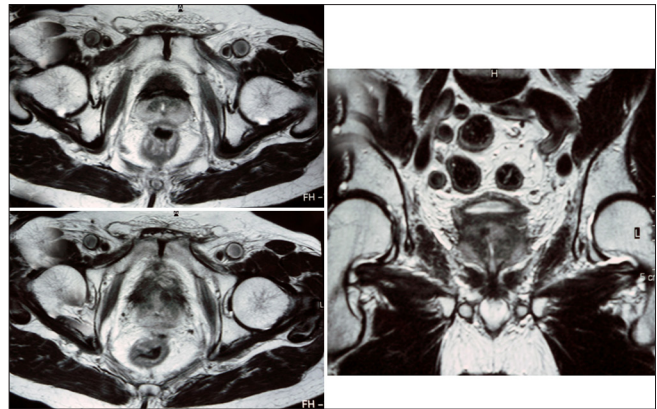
Post-treatment MRI showed a complete response of the tumor
